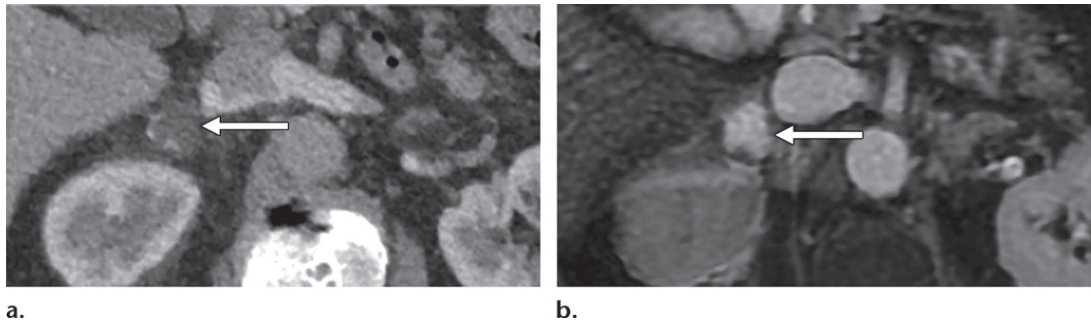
Retroperitoneal neoplasms mimicking an adrenal pathologic condition. Axial portal venous phase CT image (a) shows a right suprarenal lesion (arrow), with discontinuous peripheral nodular enhancement, which was seen to progressively fill-in, and is hyperintense on the axial fat-saturated FIESTA MR image (b). These findings are consistent with a retroperitoneal hemangioma. A review of multiplanar reformatted images (not shown) showed the lesion arising adjacent to the adrenal gland. Retroperitoneal hemangiomas can also arise from the adrenal gland itself. Imaging characteristics of retroperitoneal hemangiomas can overlap with those of ganglioneuromas, a rare larger adrenal tumor that demonstrates progressive enhancement at postcontrast imaging.
